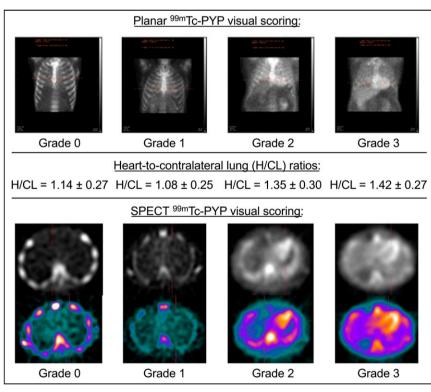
Semiquantitative visual grading. Both planar and SPECT images are used to visually score degree of cardiac amyloidosis. Amount of ^{99m}Tc-pyrophosphate uptake in myocardium is compared with that in ribs. Grade 0 (normal) = no myocardial uptake and normal bone uptake; grade 1 (equivocal) = myocardial uptake less than rib uptake; grade 2 (abnormal and suggestive of cardiac amyloidosis) = myocardial and rib uptake equal; grade 3 (abnormal and strongly suggestive of cardiac amyloidosis) = myocardial uptake greater than rib uptake; PYP = pyrophosphate.
